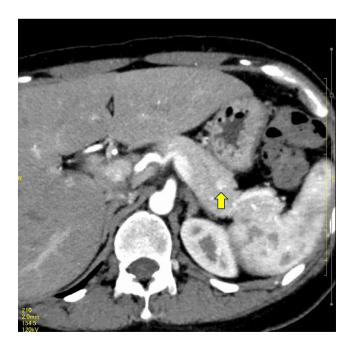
Contrast-enhanced computed tomography of the pancreas. An enhanced nodule (diameter of 13 mm) in the tail of the pancreas was revealed by contrast-enhanced computed tomography during the early phase (yellow arrow)
